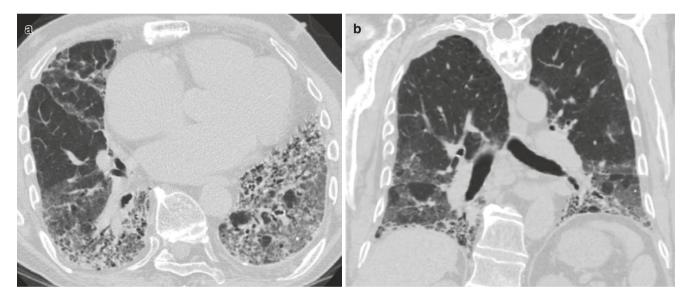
NSIP. (a, b) Axial and coronal CT images with lower lung predominant GGOs with traction bronchiectasis. Note there is no subpleural sparing
